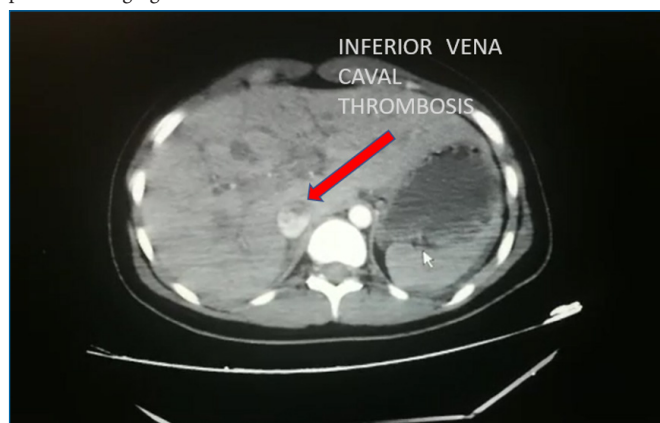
Observation of inferior vena caval thrombosis in computed tomography pulmoner angiogram.
